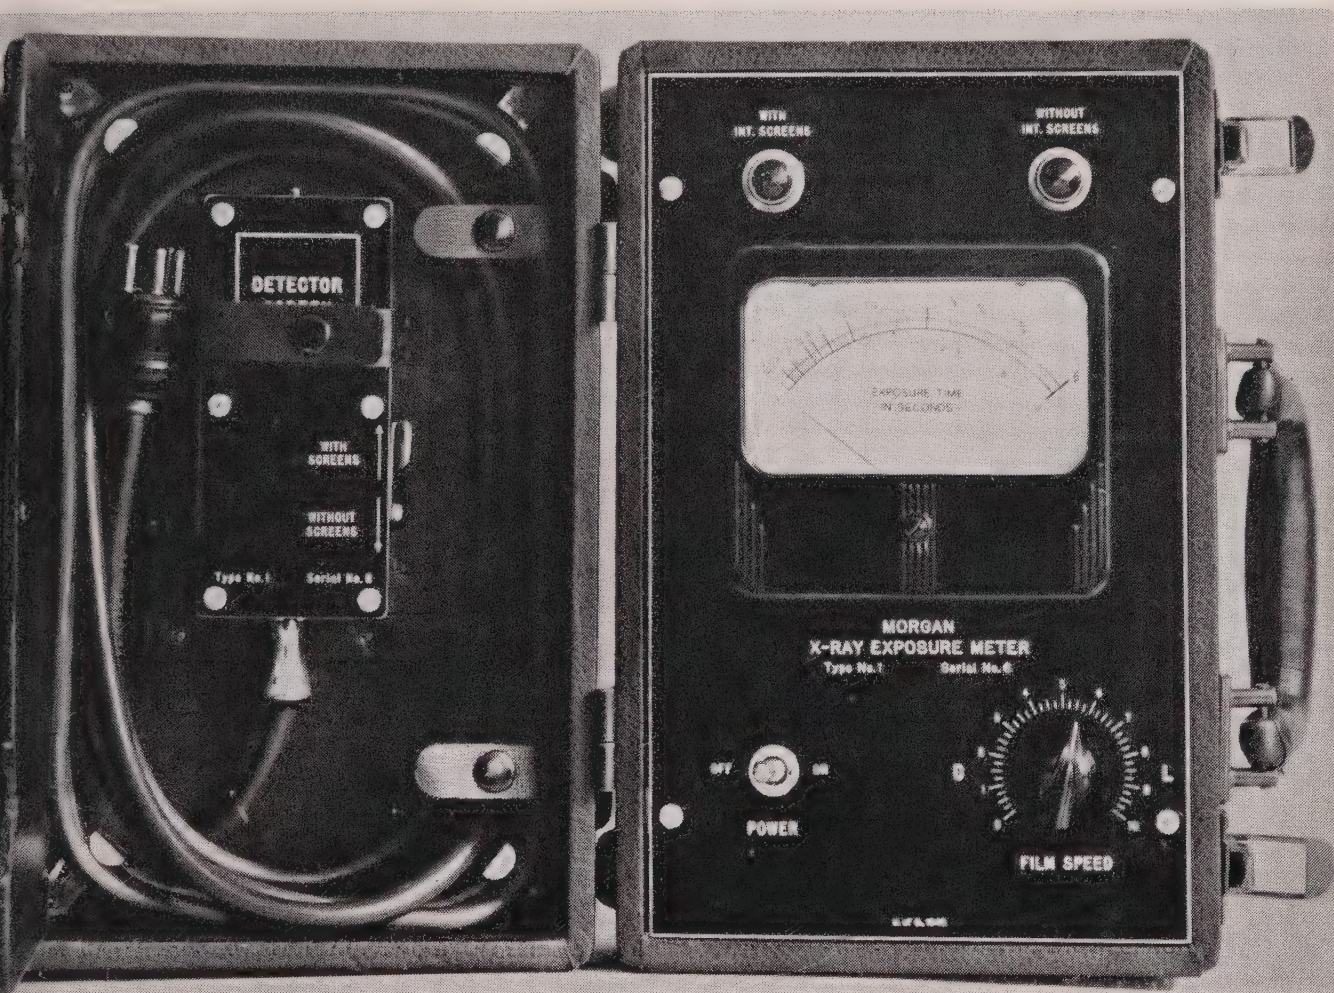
Morgan x-ray exposure meter.
